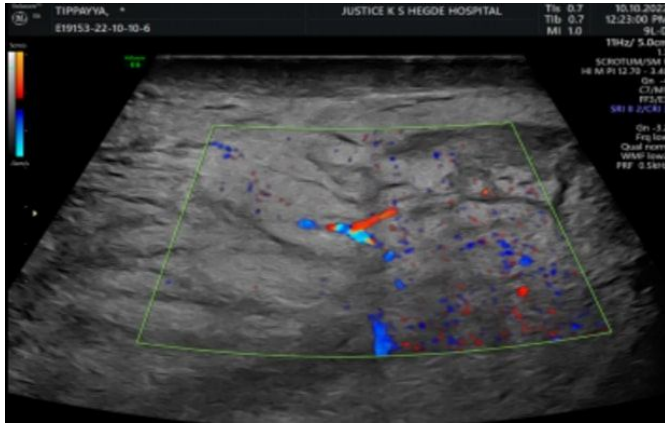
Longitudinal ultrasound view of the recurrent lesion (2022) in the right scrotum showing lobulated hyperechoic lesion with intervening hypoechoic septae with vascularity.
